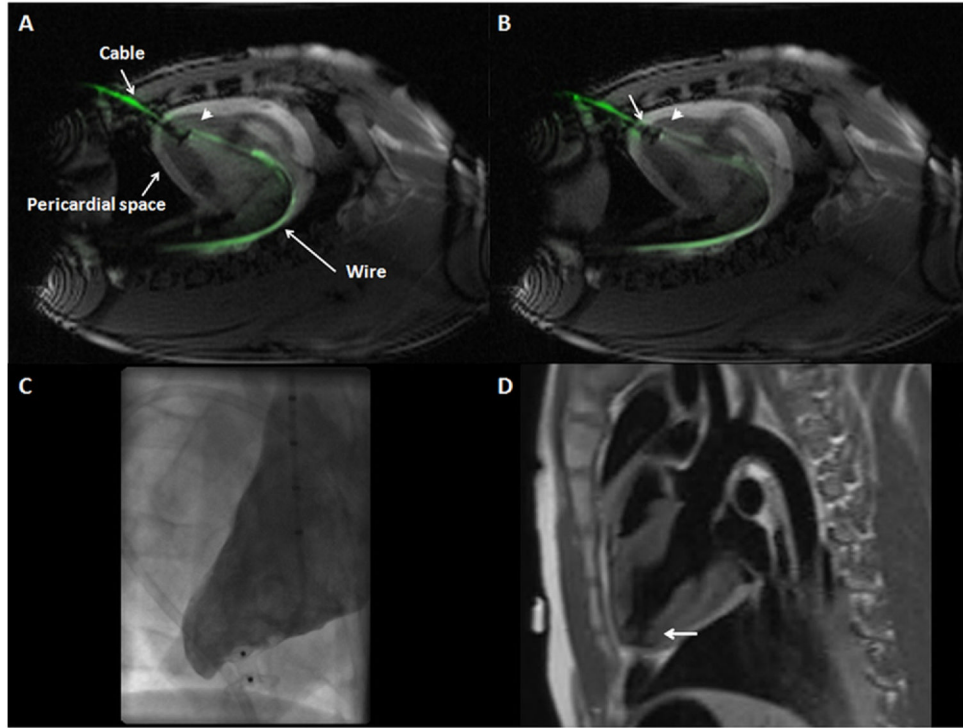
Muscular VSD Occluder Deployment Inside Myocardial Puncture Tract Guided by Real-Time MRI
